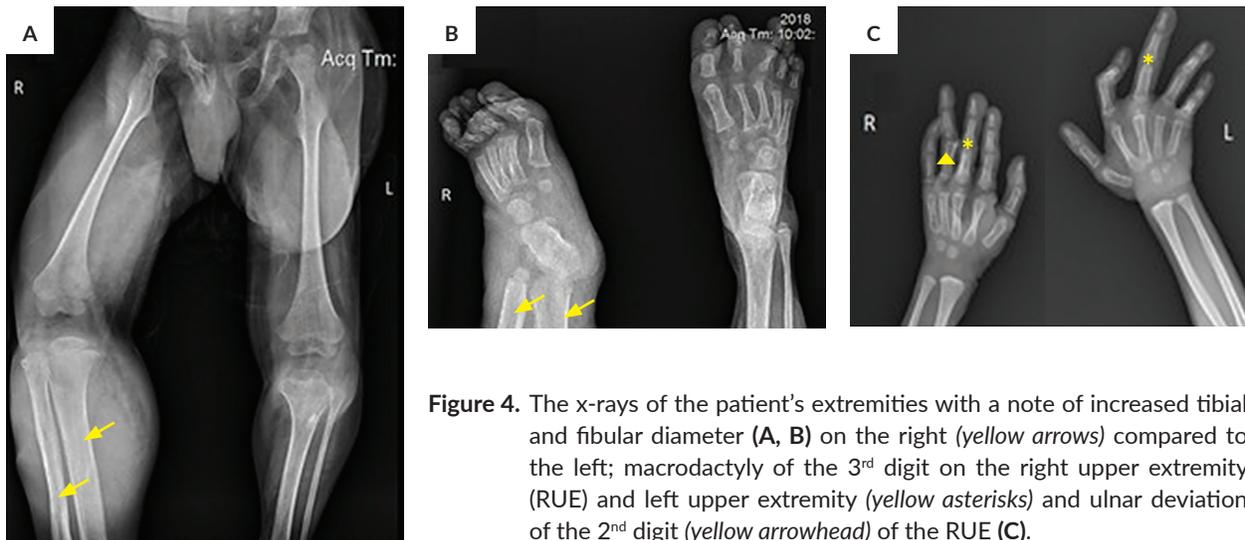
The x-rays of the patient's extremities with a note of increased tibial and fibular diameter (A, B) on the right (*yellow arrows*) compared to the left; macrodactyly of the 3rd digit on the right upper extremity (RUE) and left upper extremity (*yellow asterisks*) and ulnar deviation of the 2nd digit (*yellow arrowhead*) of the RUE (C).
